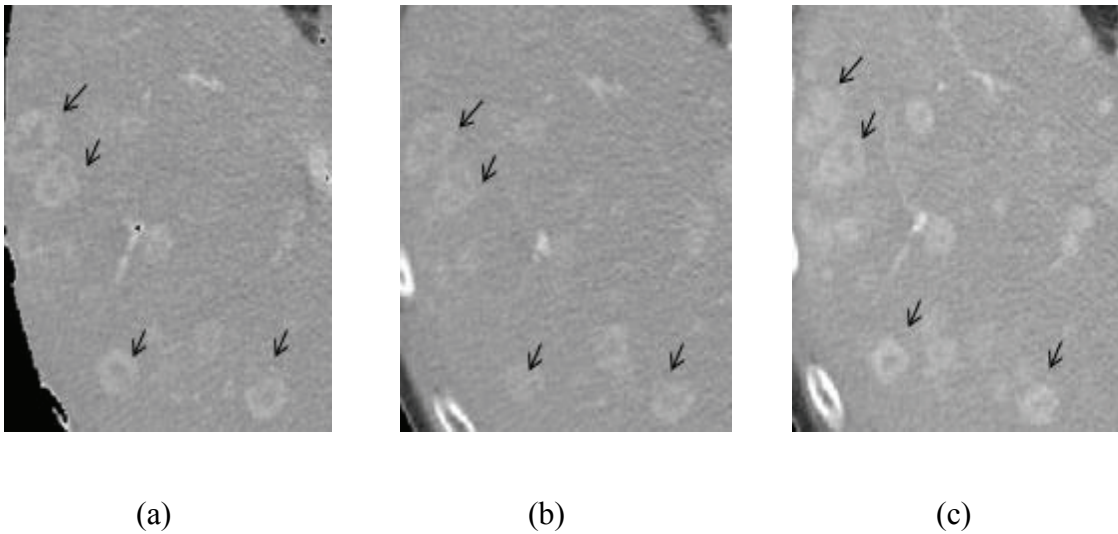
CT liver scans of patient showing gross diffuse metastatic disease (a) baseline (b) after 3 months (c) after 8 months
